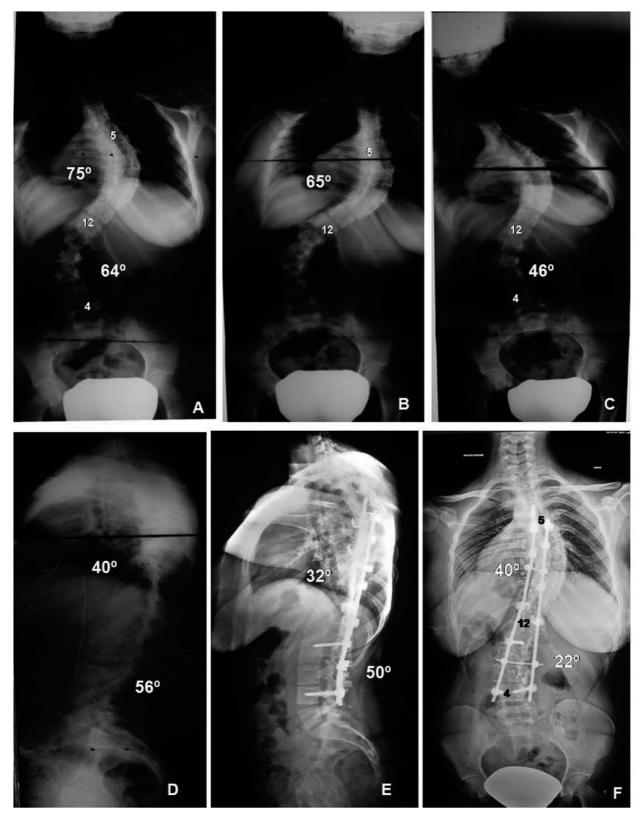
Radiographic evolution of the case with double major scoliosis (type III, according to Lenke) in a 14-year-old female. The corresponding Cobb angles and the end vertebrae are shown. A) Anteroposterior pre-op x-ray. B) and C) Anteroposterior lateral inclination x-ray. A 10° correction (13.3%) in the thoracic curve is shown and another of 18° in the lumbar curve. D) Lateral x-ray showing lumbar hyperlordosis and normokyphosis. E) Lateral x-ray 60 months after treatment, with an 8° decrease in the thoracic kyphosis and of up to 50° in the lumbar lordosis. F) Anteroposterior x-ray 60 months after treatment. Final 46.7% correction of thoracic curve and 68.7% correction of lumbar curve, at 60 months. Good axial alignment and signs of solid fusion are shown
